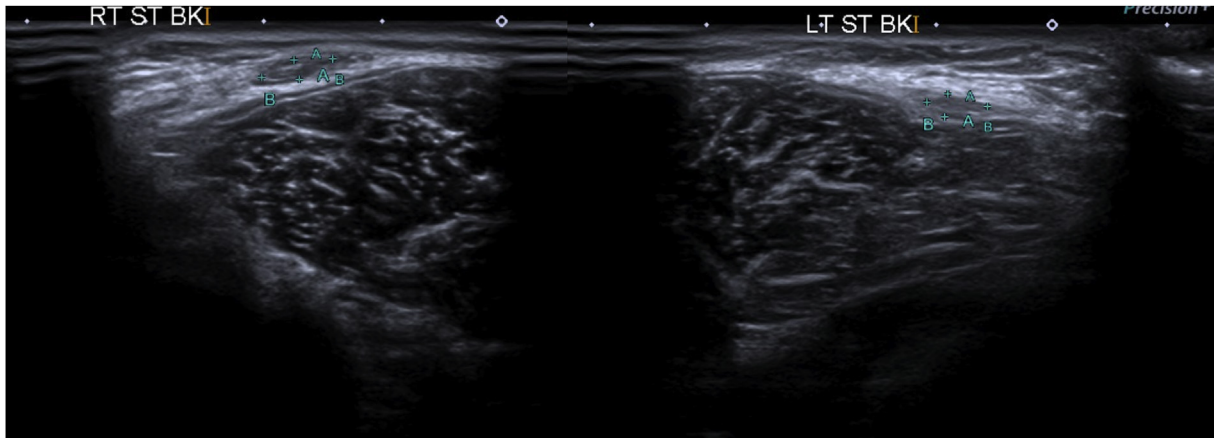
Shows ultrasonographic image of both knees (right operated). Regenerated tendon can be seen in zone 3 (1.5 cm below the lateral joint line) of the operated knee.
